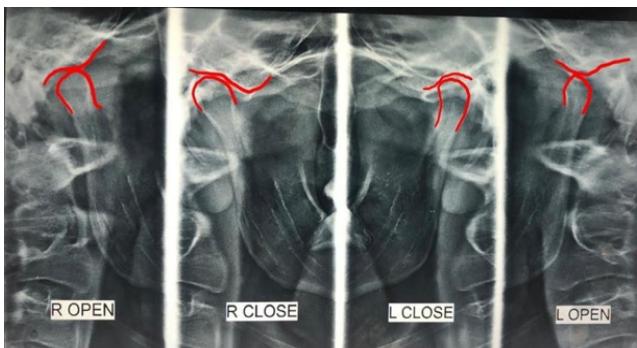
TMJ radiography imaging
